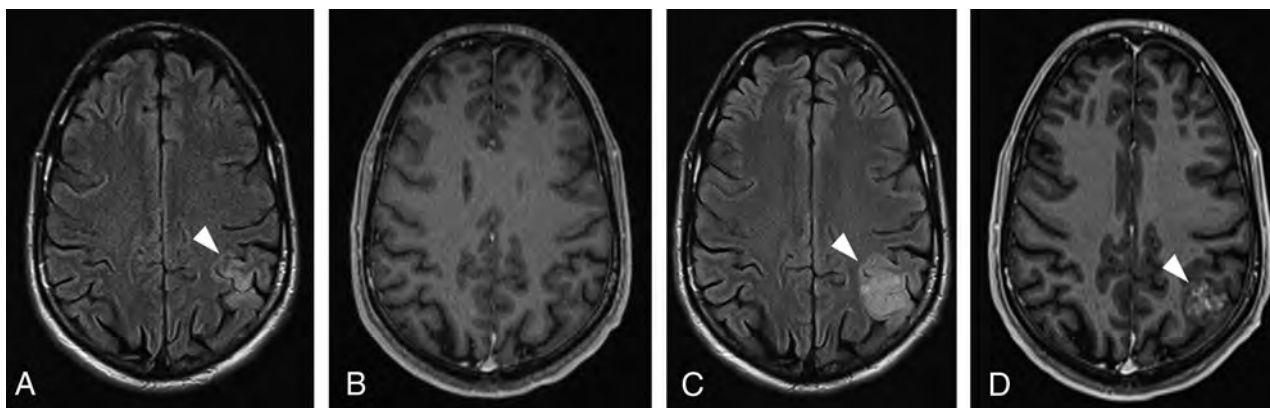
A progressive low-grade glioma in a 33-year-old man previously diagnosed with Li-Fraumeni syndrome. Initial axial FLAIR (A) and contrast-enhanced T1-weighted (B) images showed subtle cortical-subcortical FLAIR hyperintensity in the left inferior parietal lobule, with minimal expansive effect and no postcontrast enhancement, which was presumably considered to be a low-grade glial tumor (arrowhead). Two years later, axial FLAIR (C) and contrast-enhanced T1-weighted (D) images depict a marked increase in the expansive effect, with loss of gray-white matter differentiation and heterogeneous enhancement (arrowhead). Those findings are consistent with malignant transformation of a lower-grade glioma (progressive disease).
